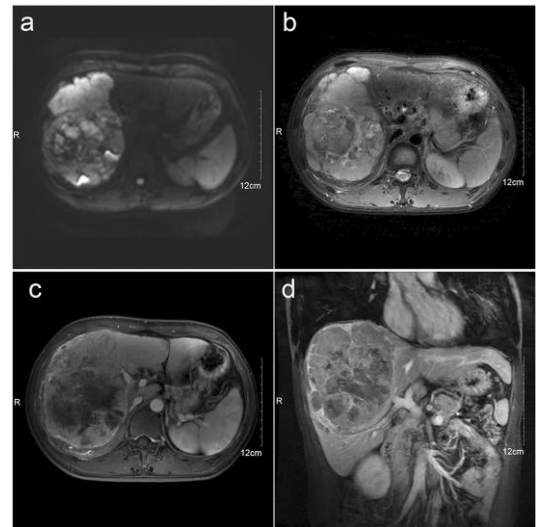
Patient B treated with TILA-TACE. Contrast-enhanced MRI images of a huge hepatocellular carcinoma (19.6 cm) in the right lobe before the first session of treatment. Huge hepatocellular carcinoma in the right lobe with rich vascular supply. (a) DWI. (b) T2WI. (c) Axial, TIWI with contrast-enhanced MRI, arterial phase. (d) Coronal, TIWI with contrast-enhanced MRI, arterial phase.
